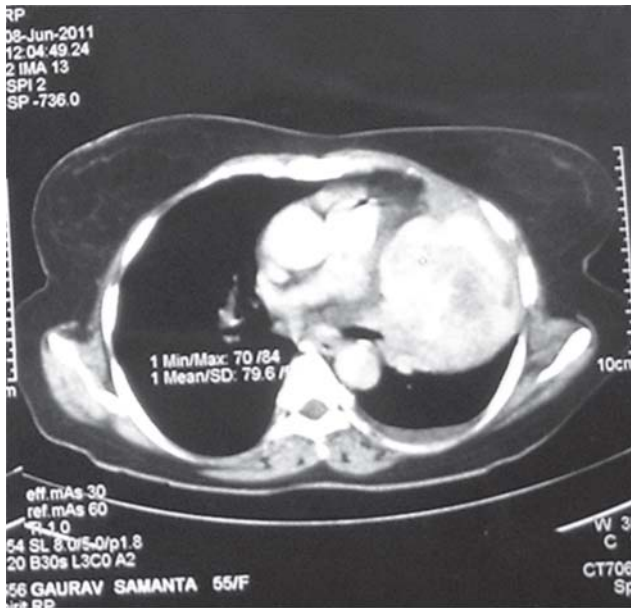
Computed tomography of chest (mediastinal window) showing a large (8cm x 9cm) heterogeneously enhancing mass lesion in the left upper lobe with central non-enhancing necrotic areas and minimal left sided pleural effusion.
